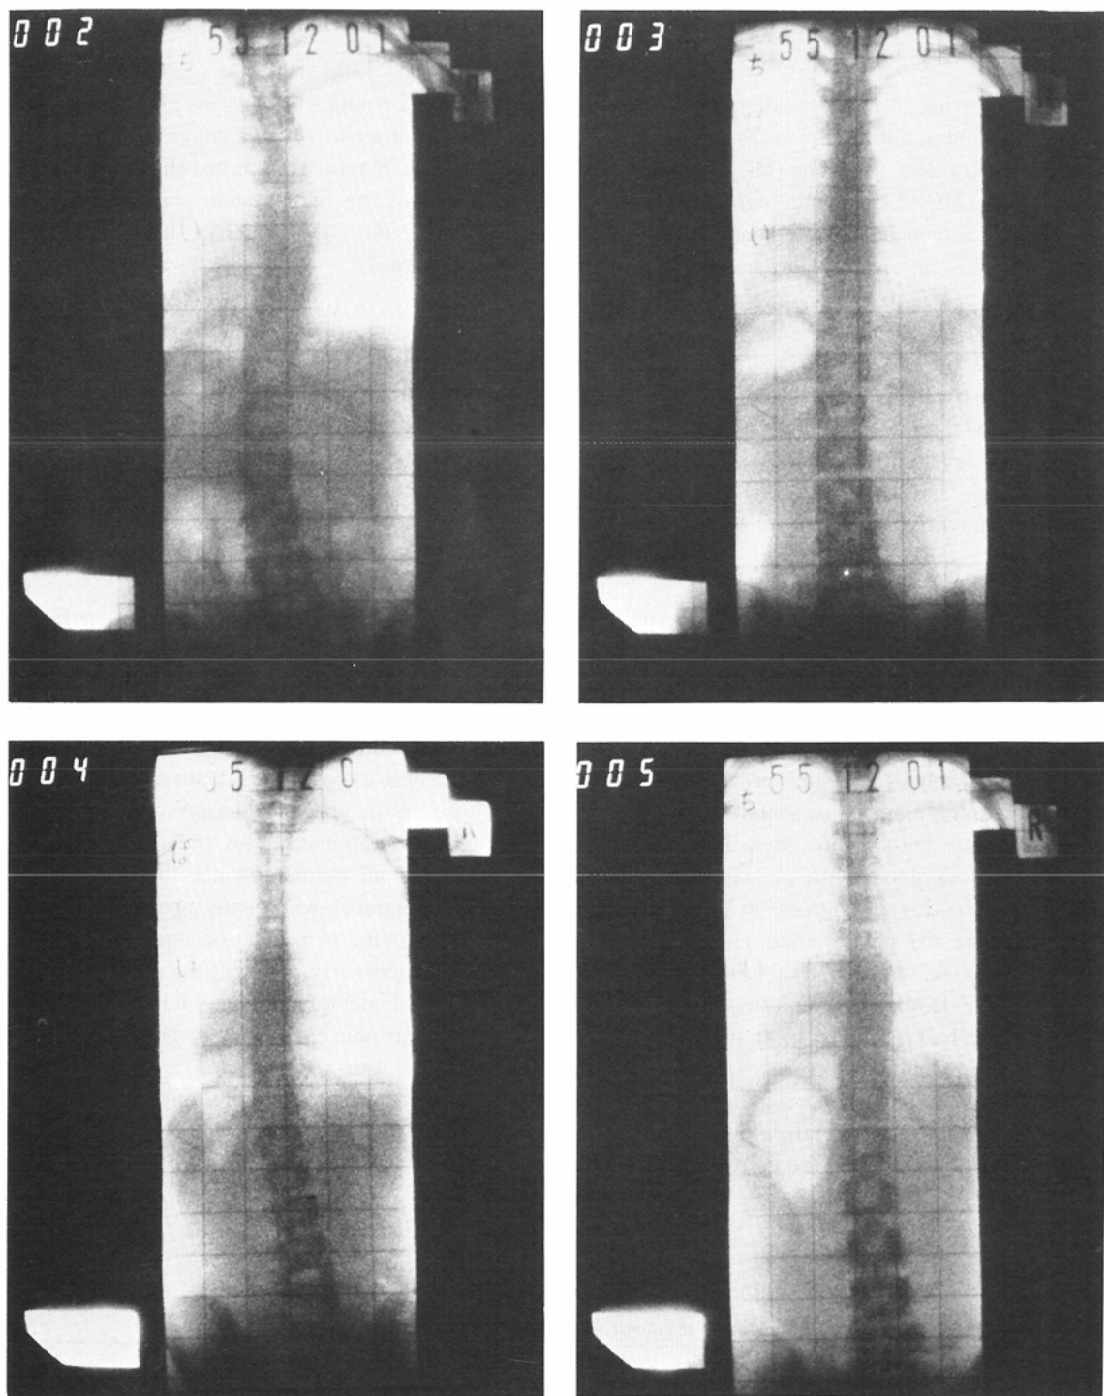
Spinal X-ray photograph obtained through a low-dose X-ray photography equipment
